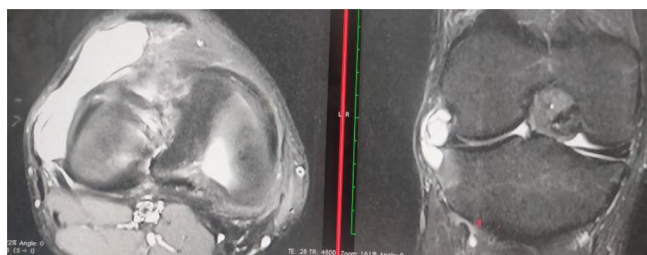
Figure A Proton density fat saturated sagittal image & Figure B STIR Coronal MRI image shows Multiple small punctuate lesions are seen involving femur and tibia – favours changes of osteomyelitis with synovial effusion and large bakers’ cyst.
